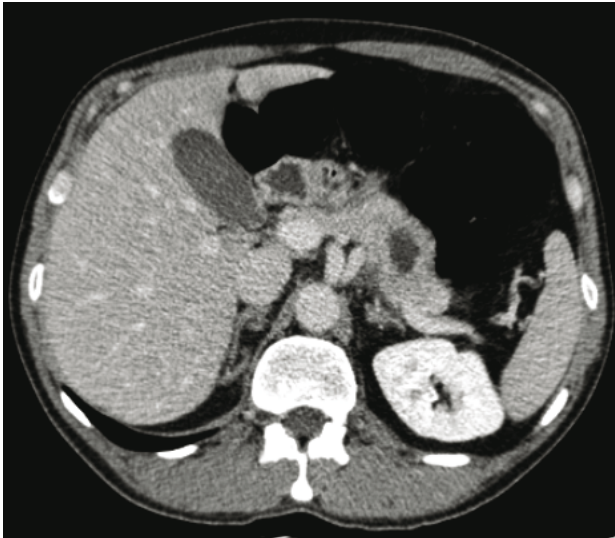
CT scan showing pancreatic tail enlargement with central cystic lesion
